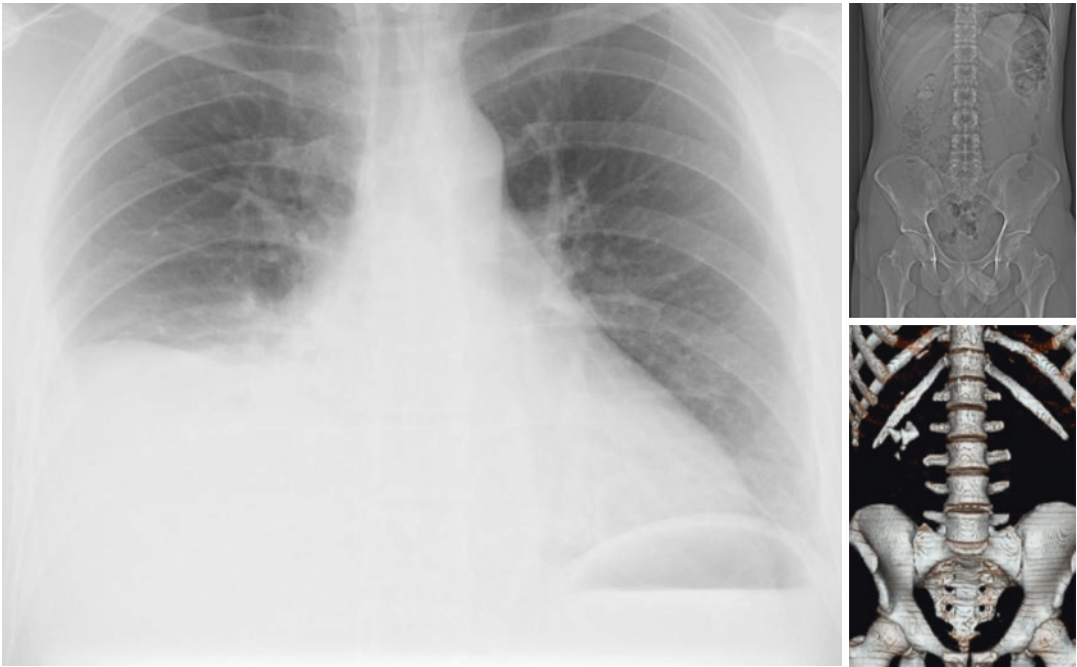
Plain chest X-ray. (PCNL was performed through an upper pole access for a right-sided partial stag-horn stone [right]. Upper calyx was dilated and accessed just above costa 12. Surgery was uneventful, and patient was rendered stone free. Postoperatively, patient developed
